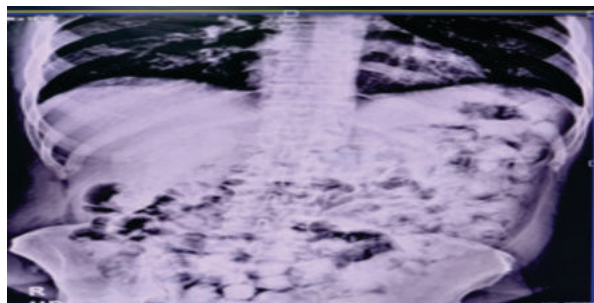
X-ray Erect abdomen on Day 2 of admission.
